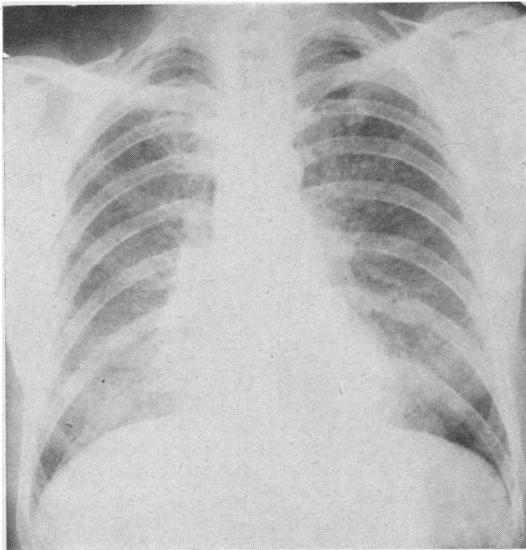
Case 1. Chest radiograph showing generalized mottling in both lungs and prominent hila.
